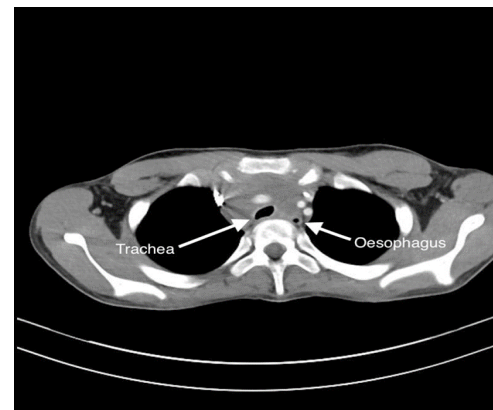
Axial computed tomography of the chest after 1 week of chemotherapy showing that the tumor did rapidly shrank and that the extrinsic compression of the mainstem bronchi disappeared.
